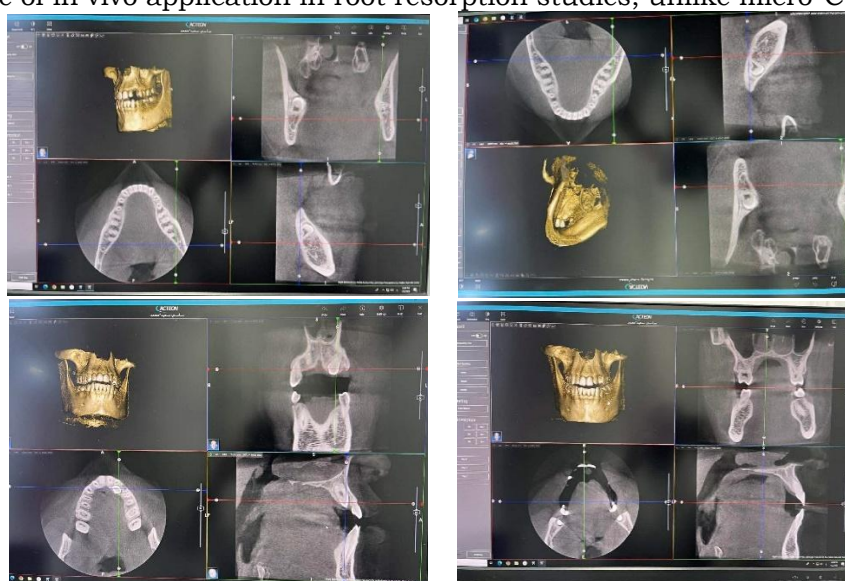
Cone beam computed tomography
